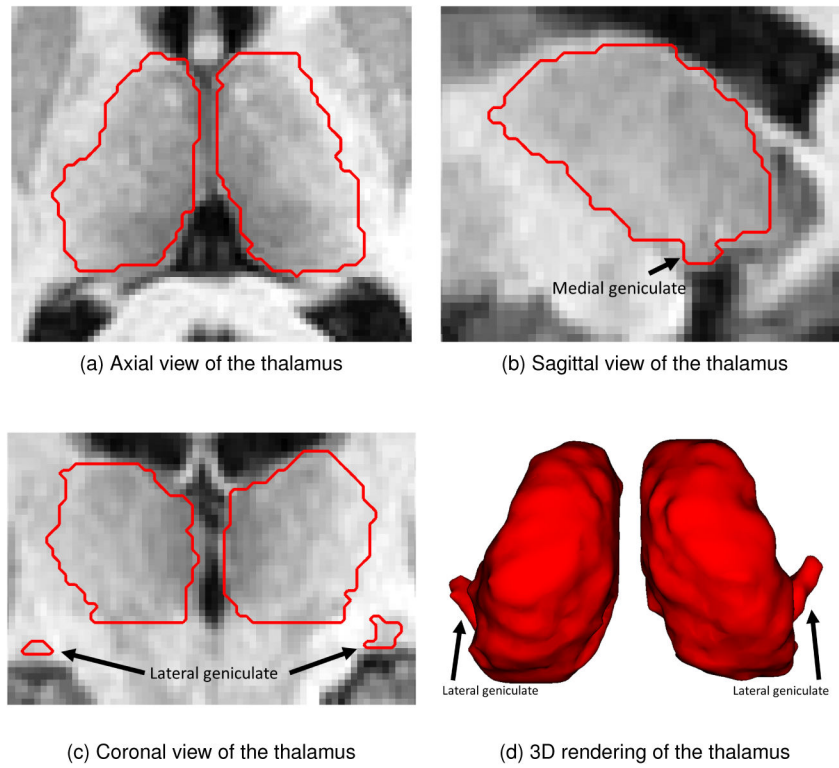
Examples of the thalamus anatomy (outlined as a red contour) overlaid on a T1-w MRI. The black arrows in the coronal and sagittal views as well as in the volumetric rendering show the locations of the medial and lateral geniculates.
